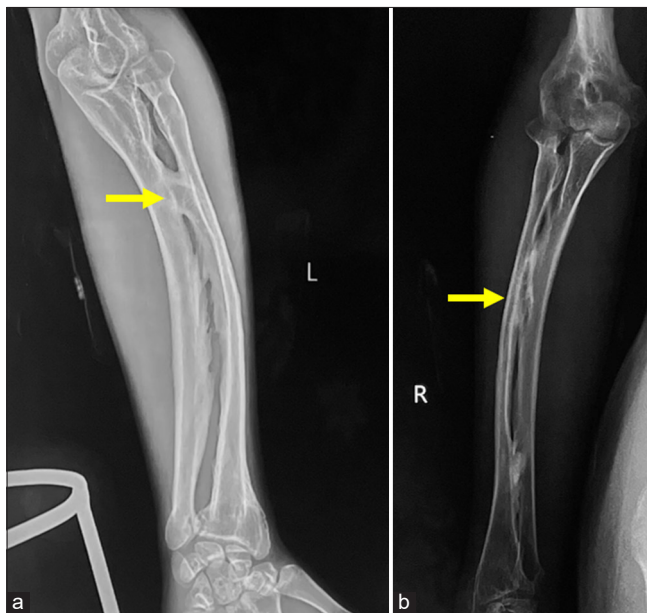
(a) Frontal radiograph of the left forearm shows ossification of the radioulnar interosseous membrane (yellow arrow). (b) Frontal radiograph of the right forearm shows ossification of the radioulnar interosseous membrane (yellow arrow).
